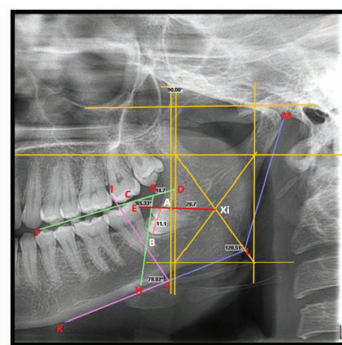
Linear and angular measurements in digital panoramic radiograph
